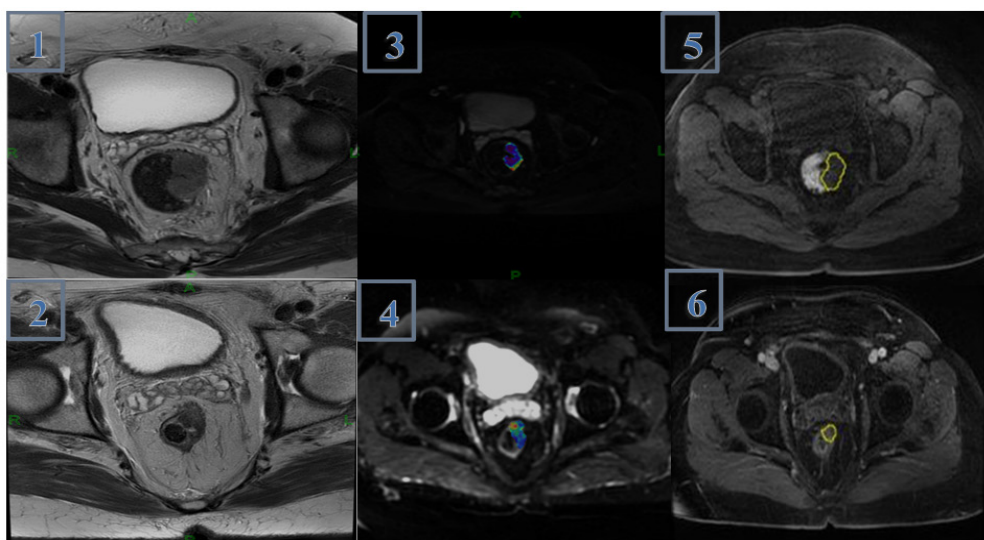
Good Response Case based on the Tumor Regression Grade (TRG) Criteria. A 63-year-old female with locally advanced colorectal cancer. Axial T2-weighted images of a T3c tumor on 1. The pre-CRT MR imaging. T2 images demonstrates the regressive change in the mass as a result of CRT (2. after CRT phase). The Ktrans shows relatively high Ktrans (2.37 min⁻¹) in 5. Pre-CRT phase.6. Ktrans significant drop after CRT MR imaging (f Ktrans 0.85 min⁻¹). After surgical resection, pathological examination revealed the complete remission status (ypT0 and TRG1), suggesting a good response due to downstage and TRG.
